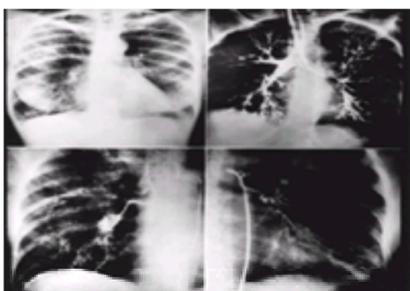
Plain chest radiograph showing right-sided infiltrate (*upper left panel*) and bronchiectasis confirmed by bronchography (*upper right panel*) in a patient presenting with severe hemoptysis. Bronchial angiography (*lower panels*) demonstrates bilateral tortuous and hypertrophied bronchial circulation, significantly more severe in the right lung, suggesting that this was the source of hemorrhage. (Reproduced courtesy of Manuel Viamonte, M.D., Department of Radiology, Mount Sinai Medical Center, Miami Beach, Florida.)
